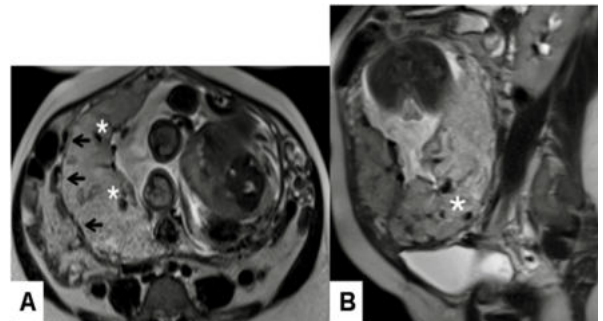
A.T2 weighted axial section of MRI showing placental vascular lacunae(white asterix) and increased retroplacental vascularity within the myometrium(short black arrows) B. Sagittal section of same MRI showing multiple placental lacunae(white asterix)
